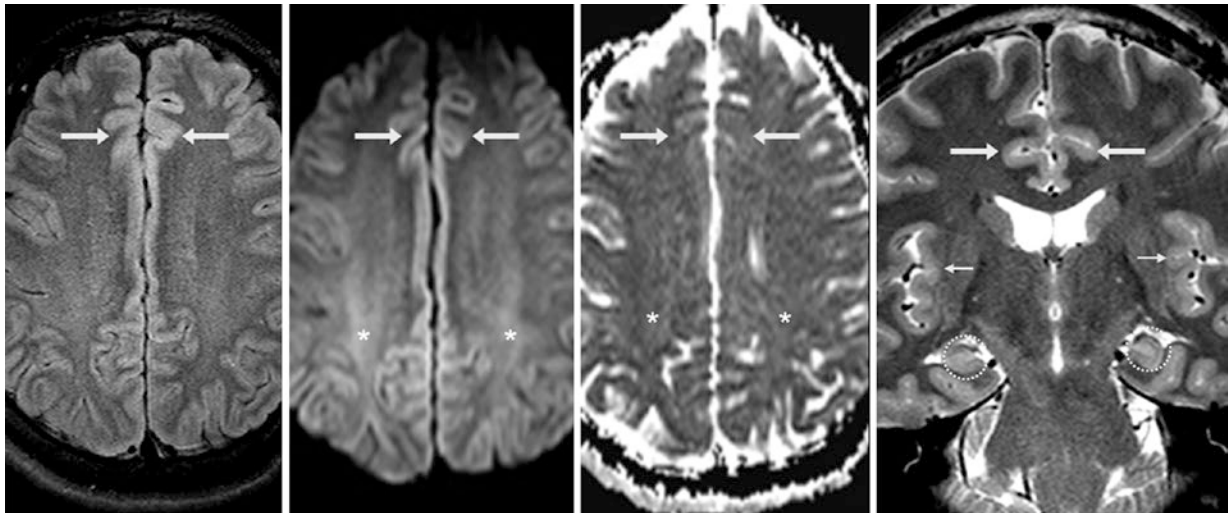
A 27-year-old underwent a 3 T MRI that shows hyperintense cortices of the cingulate (*arrows*) and insular (*thin arrows*) gyri, relative to the parieto-occipital gyri, on axial FLAIR (*left*), DWI (*left middle*), and coronal T2WI (*right*). These gyri exhibit normal signal intensity on
